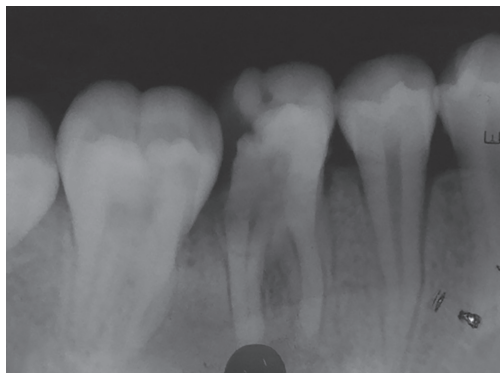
Preoperative radiograph showing distal caries with 36
